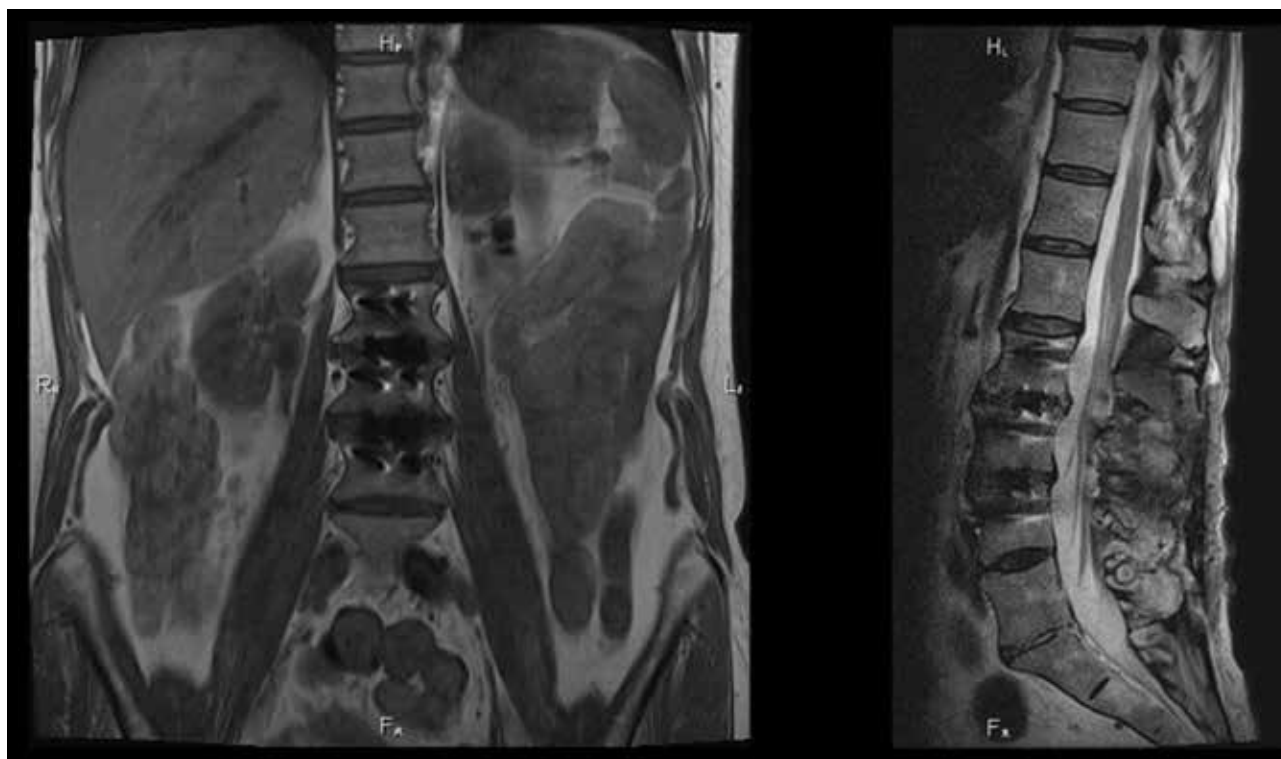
Corresponding T1 MR images show severe signal loss in the L2-L3 and L3-L4 intervertebral disc spaces and adjacent vertebral bodies due to metal artifacts which makes the study non diagnostic.
